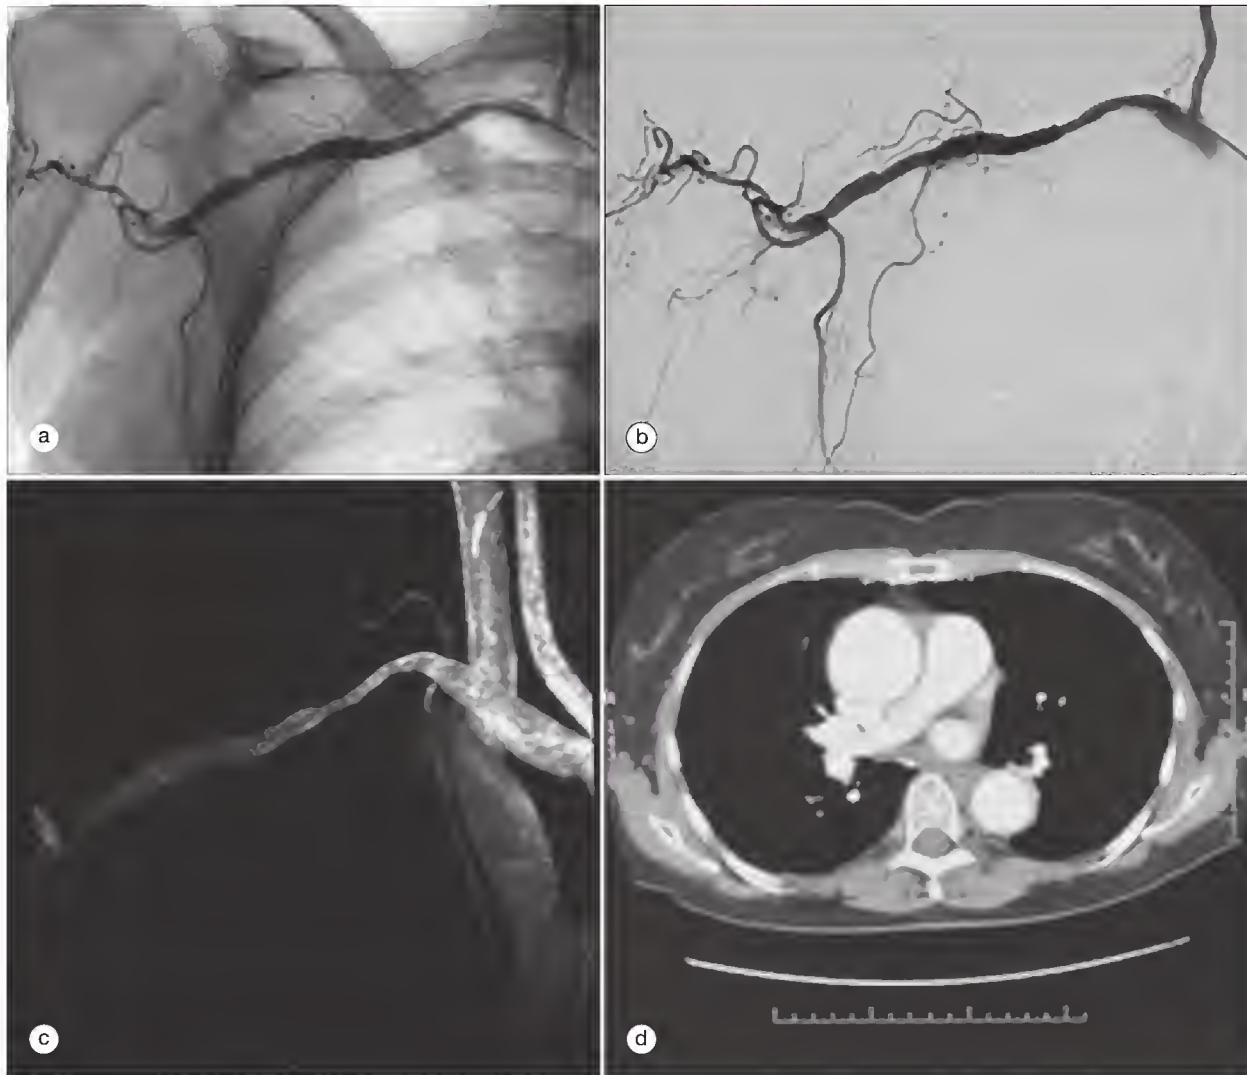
Imaging studies for giant cell arteritis. (a) Occlusion of the axillary-brachial junction. The angiogram shows irregularity of the right subclavian artery with occlusion at the axillary-brachial junction and formation of collateral vessels. (b) Digital subtraction image. (c) A magnetic resonance angiogram of the great vessels shows narrowing of the subclavian artery distal to the origin of the vertebral artery. (d) A contrast-enhanced computed tomographic image of the chest shows pronounced ectasia of the ascending aorta, minimal thickening, and irregularity of the wall.
